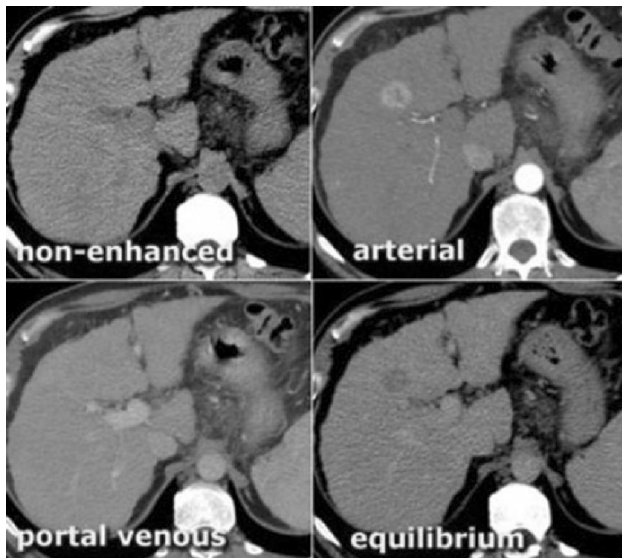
CT appearance of hepatocellular carcinoma
